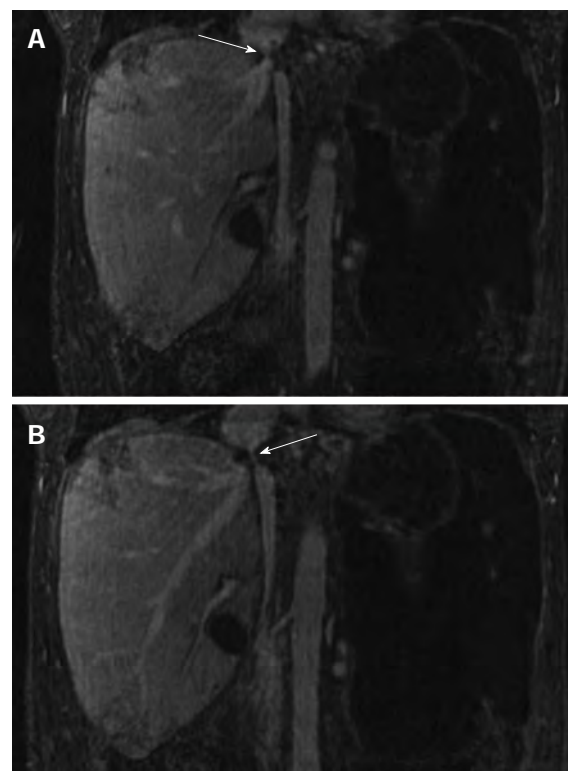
Five-minute steady state imaging. A: Coronal T1 weighted ultrafast gradient echo steady state magnetic resonance imaging image obtained 5 min following administration of Gadofosveset trisodium demonstrates inferior vena cava stenosis (white arrow); B: Coronal T1 weighted ultrafast gradient echo steady state magnetic resonance imaging image obtained 5 min following administration of gadofosveset trisodium demonstrating patent, but stenosed transplant hepatic vein (white arrow).
